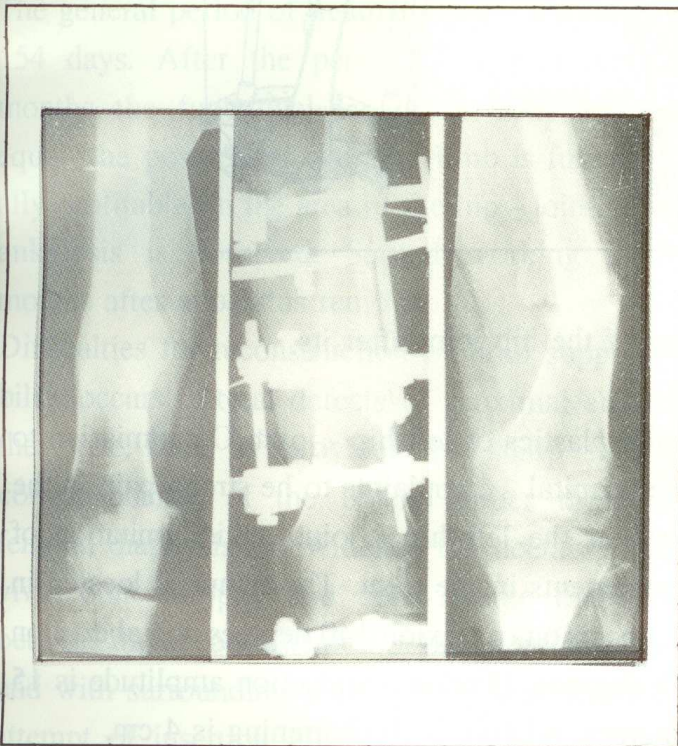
Patient abd the X-ray in 1 year after apparatus removal
